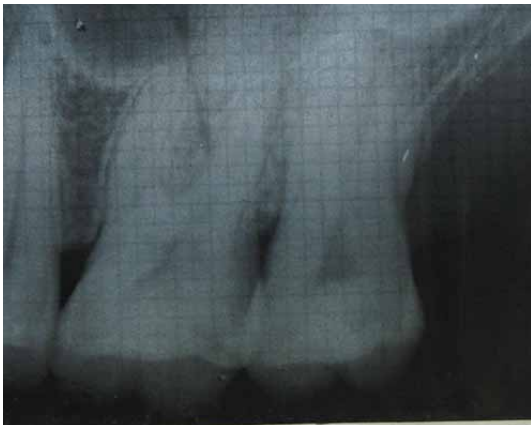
12 months post-operative radiograph.
